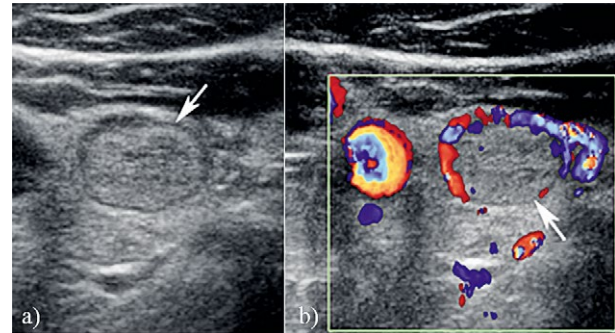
Benign isoechoic nodule in a 49 year old female with multiple thyroid nodules: a) B-mode and b) color Doppler US shows an isoechoic nodule (arrow) in the right lobe with regular margins, hypoechoic halo, well-defined margins and no calcifications (benign nodule at biopsy).
